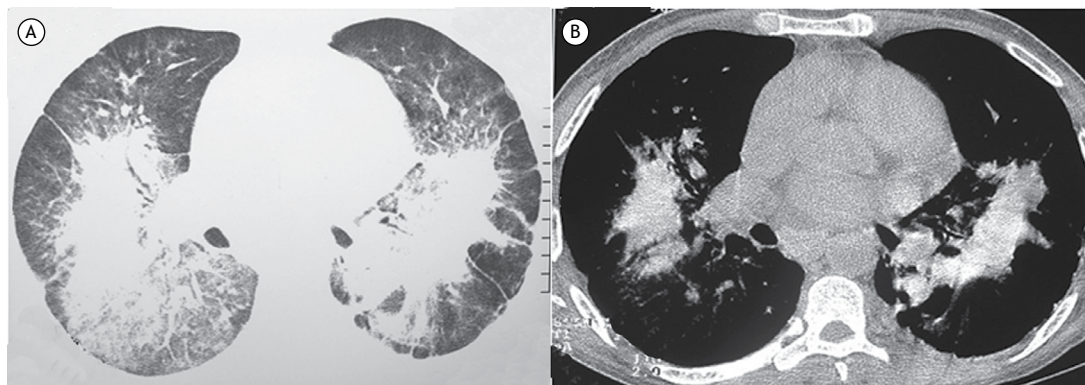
CT scans of the lower lobes with lung window setting (in A) showing bilateral conglomerate masses, ground-glass opacities, areas of emphysema, and dense streaks in the periphery. In B (mediastinal window setting), areas of increased attenuation within the conglomerate masses are revealed, compatible with talc deposition.
